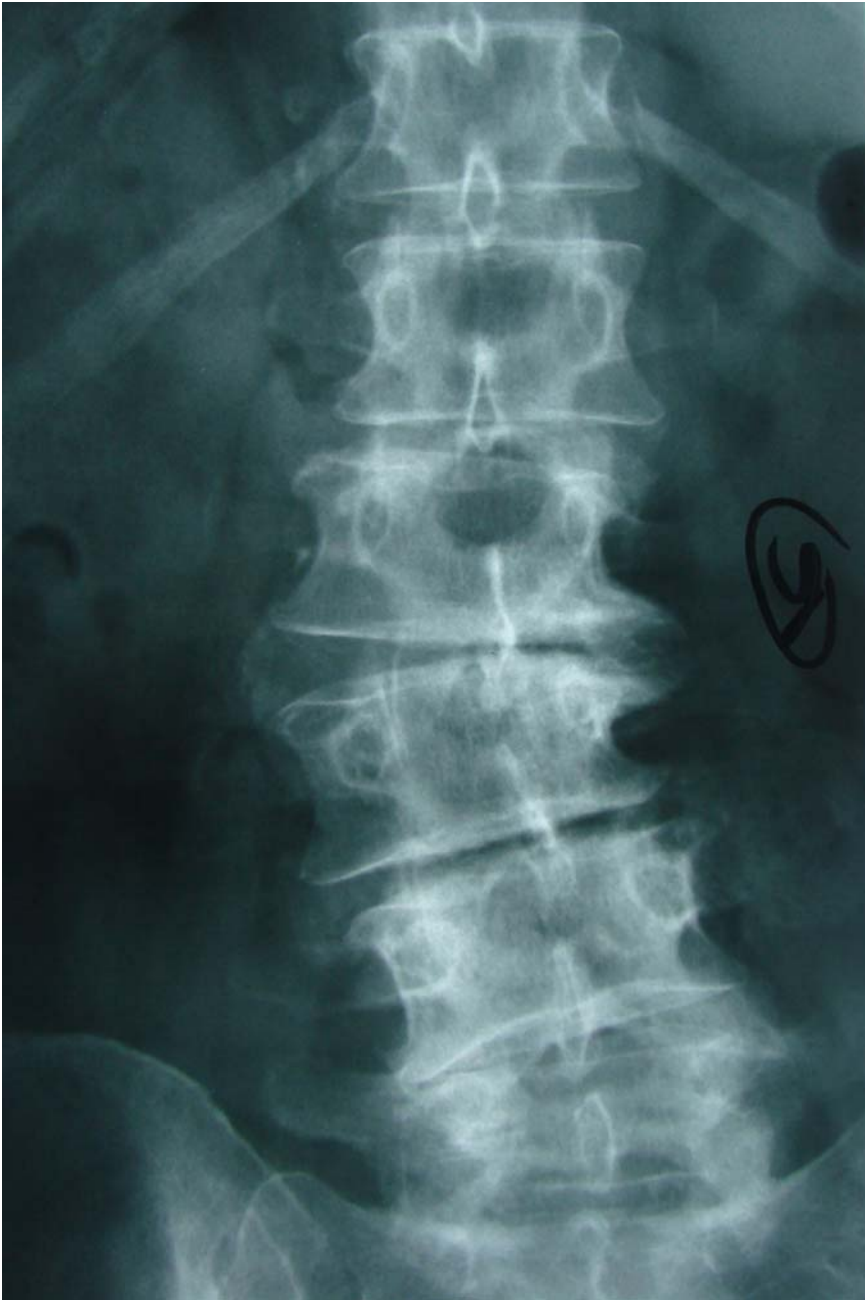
is the anteroposterior plain x-ray study showing the scoliosis and discogenic changes responsible for the spinal stenosis and resultant sciatic radiculopathy shown on MRI below
